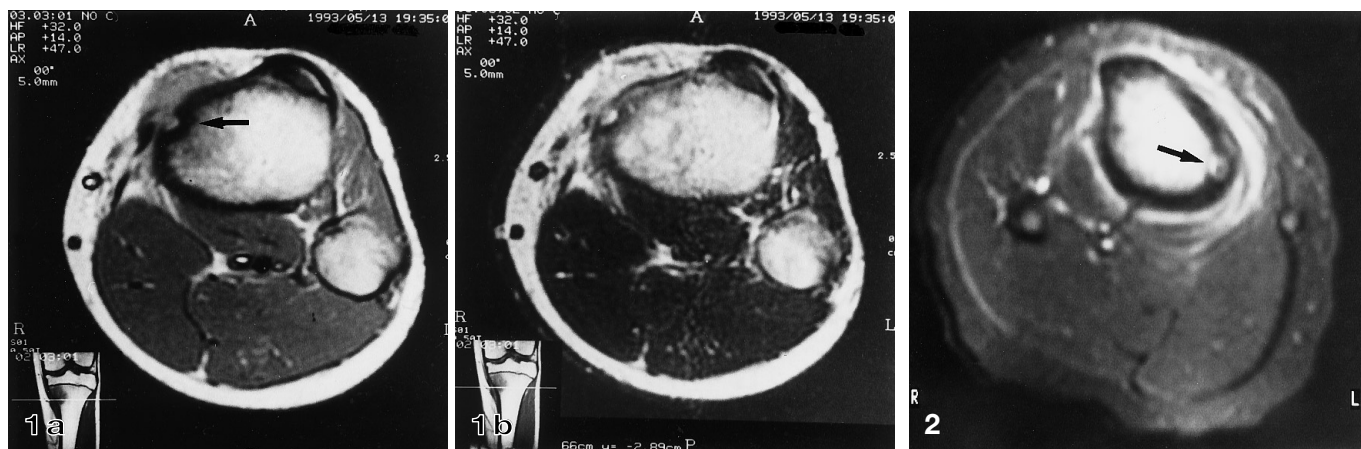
Metaphyseal osteoid osteoma with soft tissue involvement. a The transverse T1-weighted MR image shows the cortical nidus surrounded by a sclerotic rim (arrow). There is low signal intensity in the adjacent soft tissue mass and bone marrow. b The transverse T2-weighted MR image demonstrated high signal intensity within the nidus, and in the soft tissue mass and bone marrow edema
